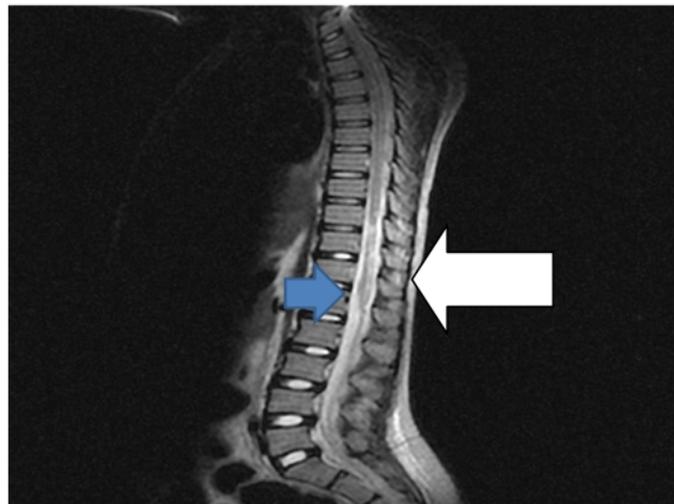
Sagittal view of T2 weighted spinal MRI showing areas of hyper intensities on many segments of the spinal cord and spinal nerve roots
